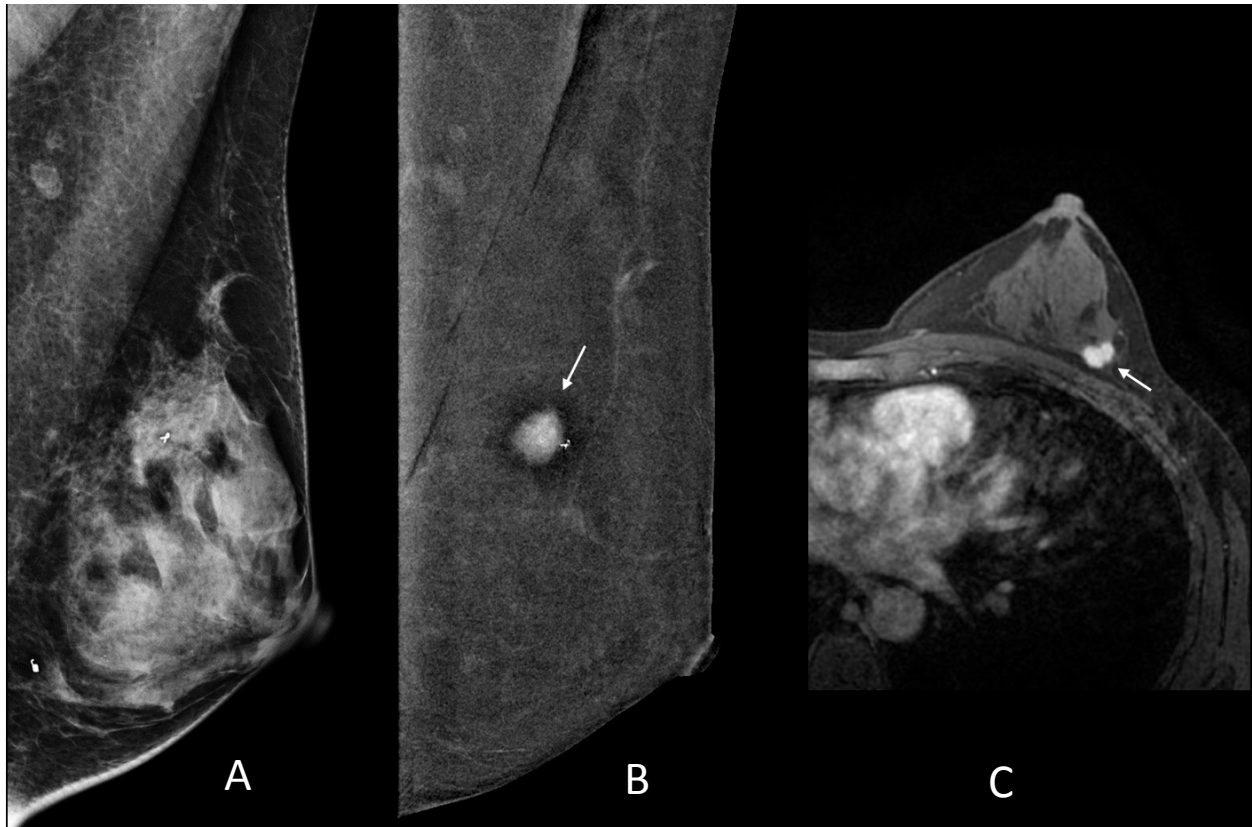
Contrast-enhanced digital mammography study of a 54-year-old female with a previously biopsied grade 2 invasive ductal carcinoma of the left breast. A. Low- energy MLO mammogram (equivalent to a standard unenhanced mammogram) shows the metallic marker at the cancer site, but the cancer is obscured by heterogeneously dense parenchyma. B. Corresponding dual-energy subtraction image clearly depicts the cancer (arrow) as an intensely enhancing irregular mass. Note that the background non-enhancing fibroglandular tissue is subtracted out. C. Image from a contrast-enhanced MRI performed the following day shows the lesion as an enhancing irregular mass (arrow). Note the similarity of the appearance on the CEDM and MRI studies.
